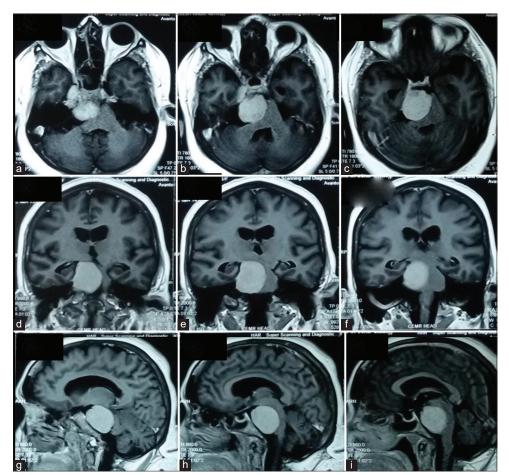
(a-c) Contrast-enhanced magnetic resonance imaging (CEMRI) axial section showing contrast-enhancing lesion in the right incusral space causing mass effect on adjacent structures. (d-f) CEMRI coronal section showing tumor extending in the supra and infratentorial compartment and compressing medial part of temporal lobe and brain stem. (g-i) CEMRI sagittal section showing tumor anterolateral to the brain stem and posterior to clivus.
